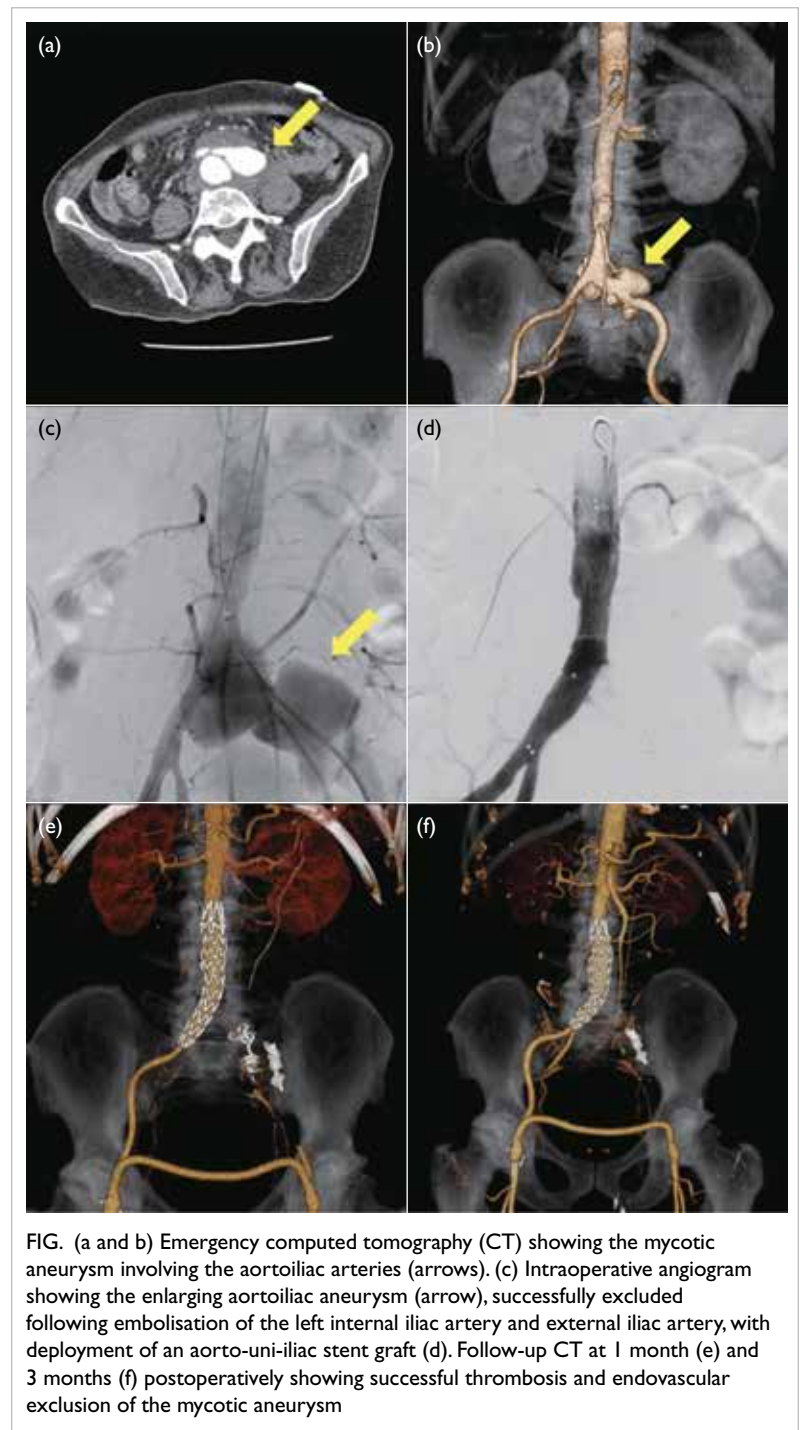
(a and b) Emergency computed tomography (CT) showing the mycotic aneurysm involving the aortoiliac arteries (arrows). (c) Intraoperative angiogram showing the enlarging aortoiliac aneurysm (arrow), successfully excluded following embolisation of the left internal iliac artery and external iliac artery, with deployment of an aorto-uni-iliac stent graft (d). Follow-up CT at 1 month (e) and 3 months (f) postoperatively showing successful thrombosis and endovascular exclusion of the mycotic aneurysm
